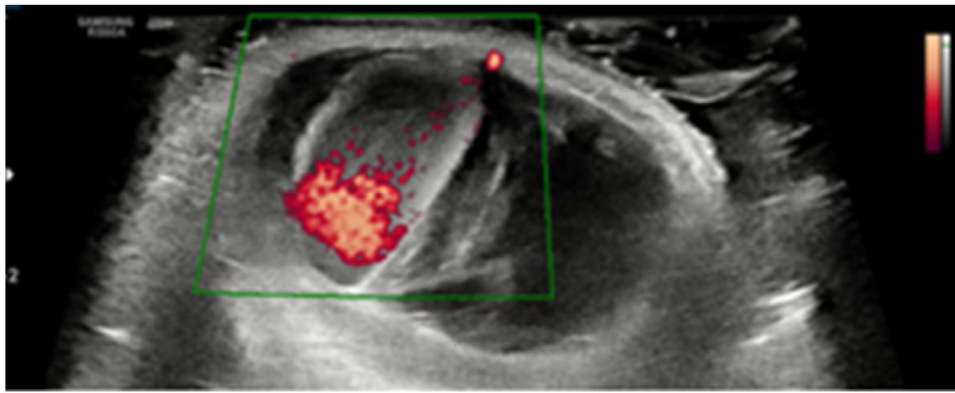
Ultrasound imaging of lesion.
